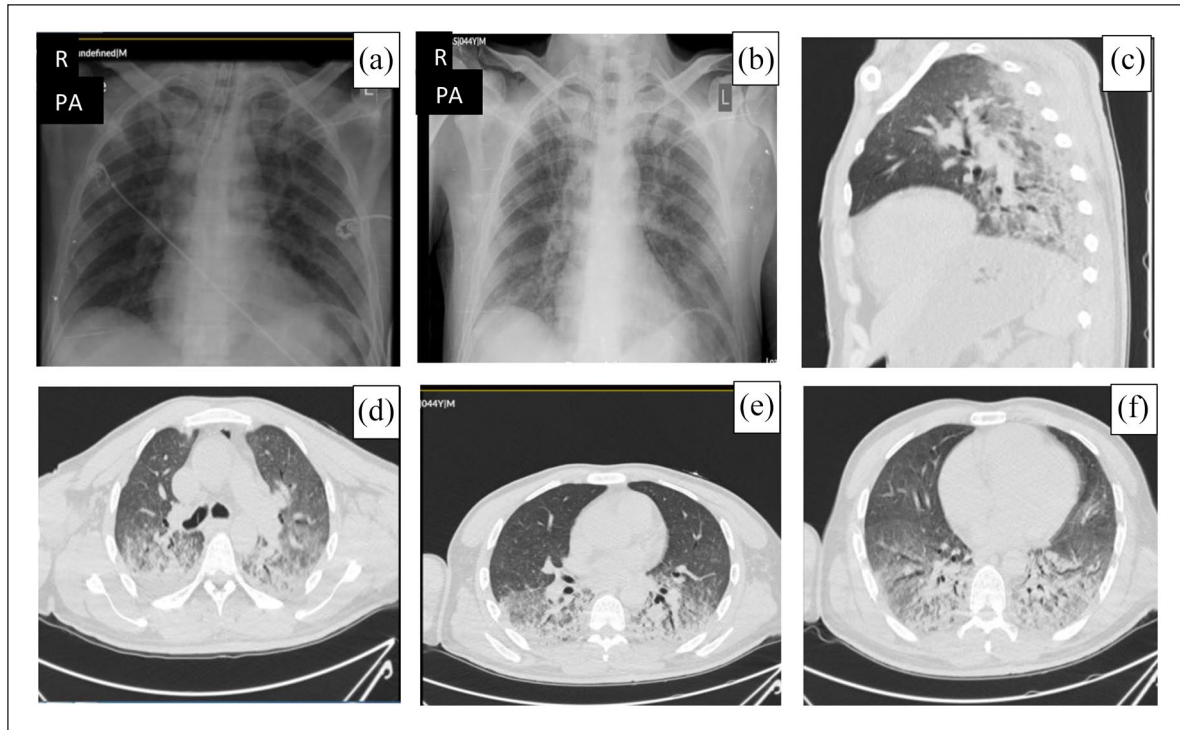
High-resolution computed tomography (HRCT) and chest X-rays (CXRs). (a) Anterior–posterior (AP) CXR on the first day of hospitalization. (b) AP CXR on the second day of hospitalization. (c) Lateral CXR on the second day of hospitalization. (d–f) HRCT section of the patient on the second day of hospitalization.
